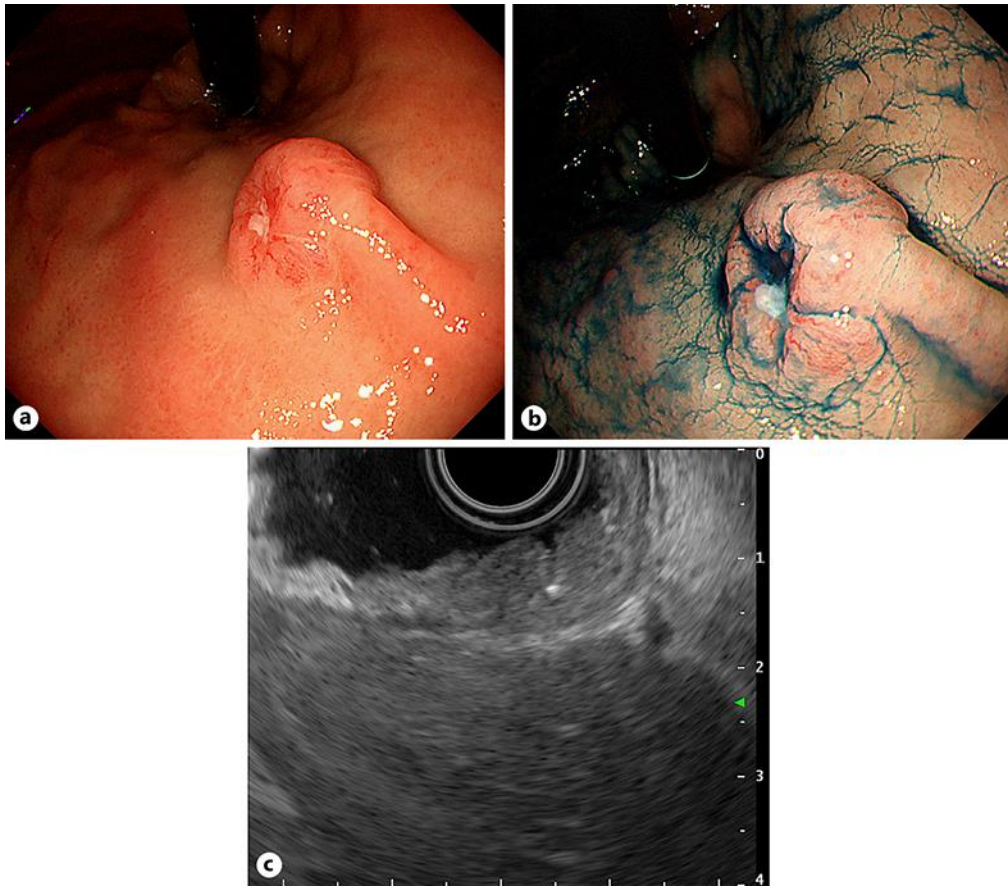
EGD findings. EGD shows a 2-cm lesion resembling a submucosal tumor in the upper gastric body at the lesser curve (a, b). Endoscopic ultrasonography demonstrates that the lesion is mainly located in the submucosa and propria muscularis (c).
